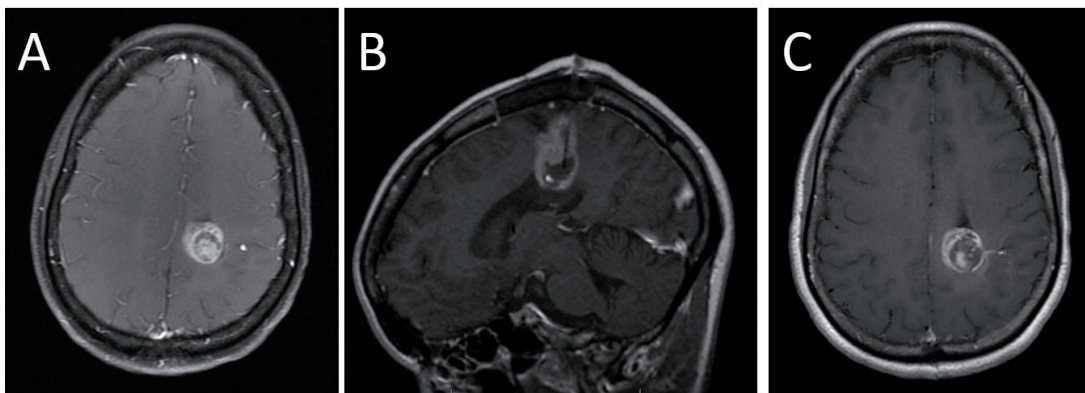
(A) A 37-year-old female with periventricular ring-enhancing mass abutting the left motor strip on axial T₁-weighted MRI with contrast. (B) Intraoperative sagittal MRI showing laser catheter trajectory. (C) Immediate post-operative axial T₁-weighted MRI with contrast demonstrating near-total lesional ablation.
